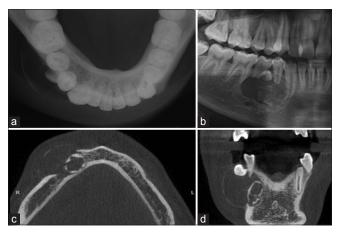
Case 1 (a) mandibular occlusal. (b) Cropped orthopantomograph image. (c) Axial section of cone beam computed tomogram. (d) Coronal section of cone beam computed tomogram
